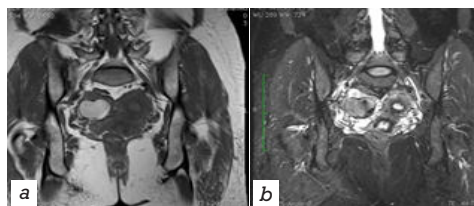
T1coronal, T2stir Coronal MRI shows left ovarian endometriotic cyst with T2 Dark Spot
